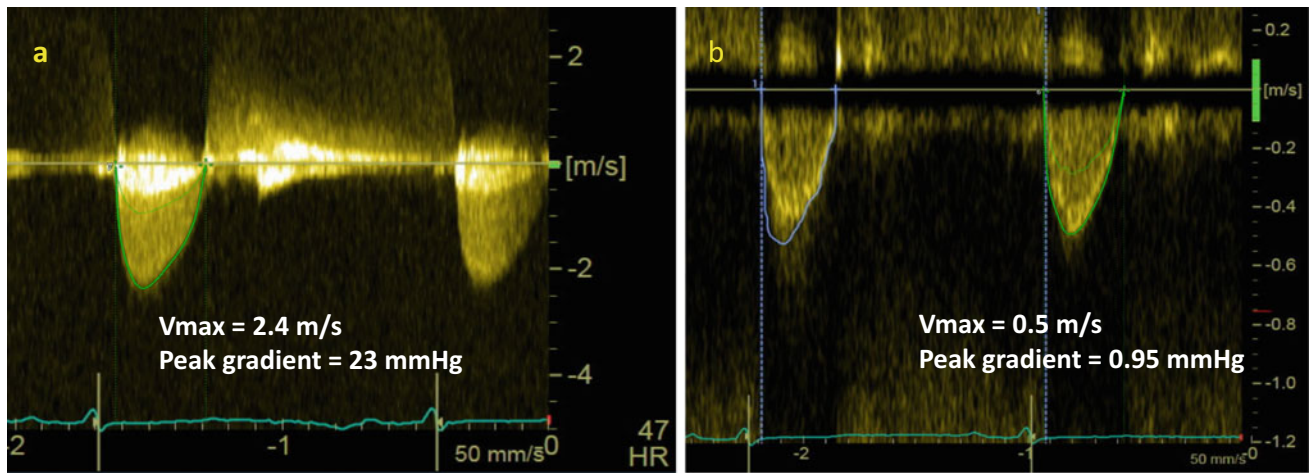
a Continuous wave Doppler through aortic valve and b pulse wave Doppler through the left ventricular outflow tract showing a peak velocity of 2.4 m/s, peak gradient of 23 mmHg through the aortic valve. Dimensionless index is 0.22. The aortic valve area calculated by continuity equation is 0.7 cm² (indexed to body surface area 0.35 cm²/m²). Measurements consistent with low-flow low-gradient severe aortic stenosis. *V*_{max}, maximum velocity
